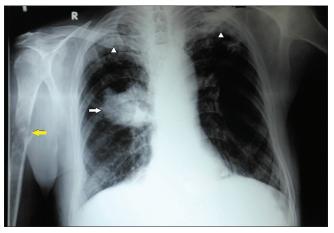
Chest X-ray (PA) showing right hilar mass (indicated by white arrow) with right humeral fracture (indicated by yellow arrow) along with bilateral apical nonhomogeneous opacity (indicated by arrowheads)
